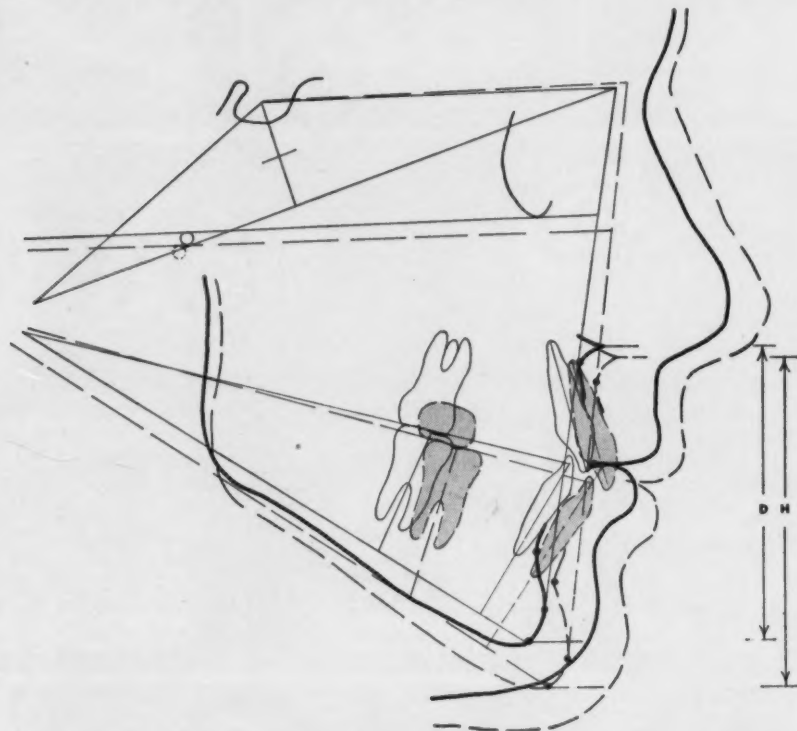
Patient A. McK. Superposed tracings of cephalometric roentgenograms. Hawley bite plate used as anchorage for Class III mechanics to increase arch length for anterior mandibular alignment. Note stability of maxillary denture. Solid line, January, 1954; broken line, February, 1956.
